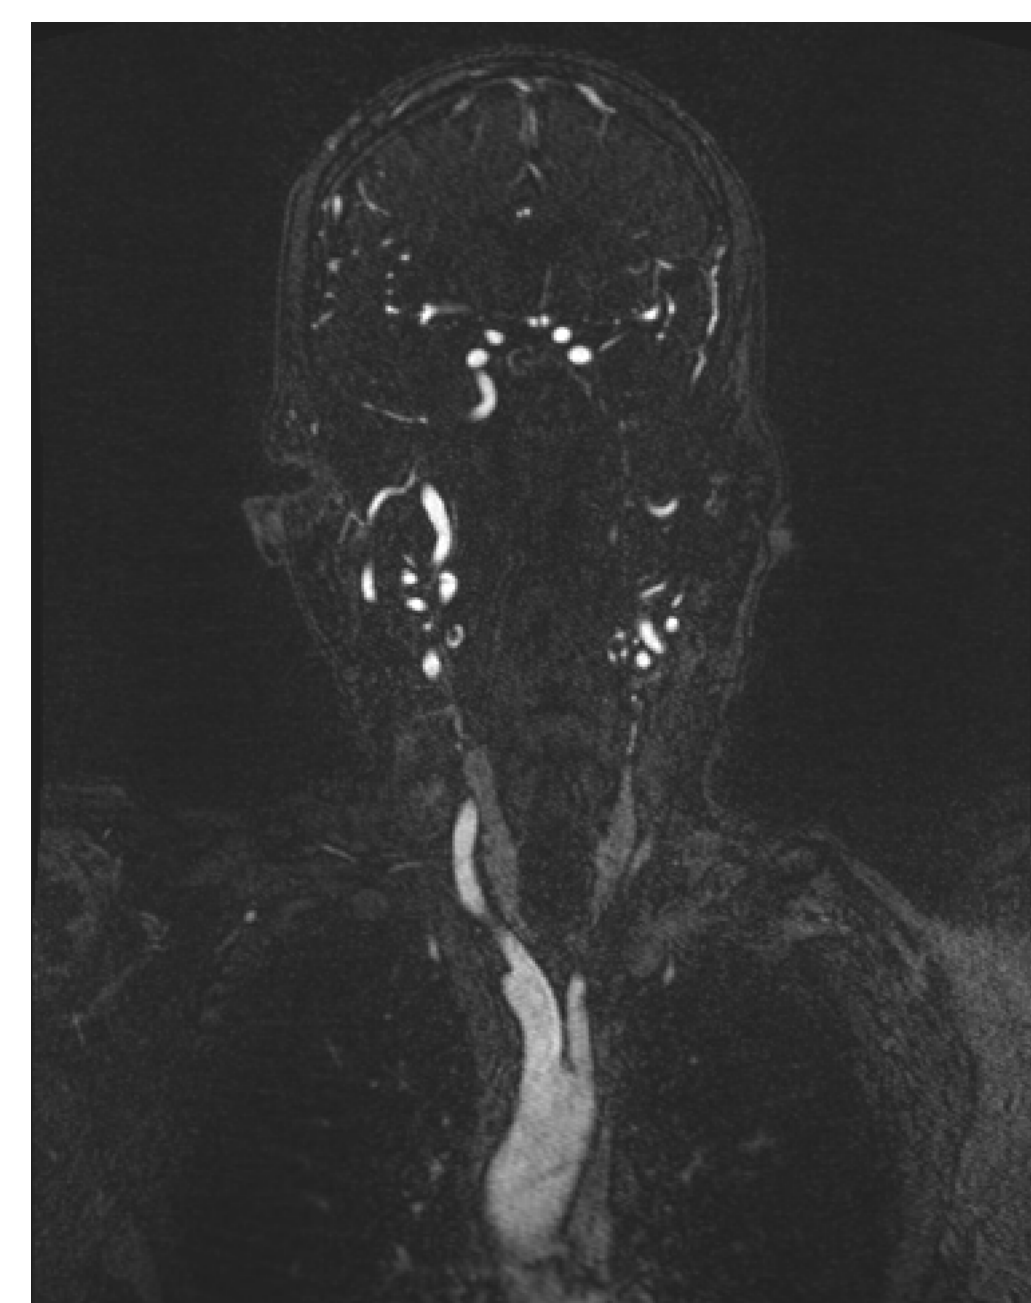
Coronal view of head and neck CTA
